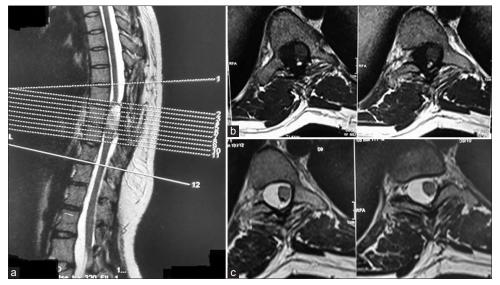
(a) Magnetic resonance imaging dorsolumbar spine showing well-defined intradural extramedullary mass lesion on the right side of the spinal canal extending from the D7/D8 to D8/D9 levels. (b) Magnetic resonance imaging showing isointense to hypointense mass lesion with signal intensity nearly comparable to the cord (e.g., isointense) on T1-weighted images (c) Magnetic resonance imaging showing hyperintense signal intensity of the lesion on T2-weighted images with associated mass effects
